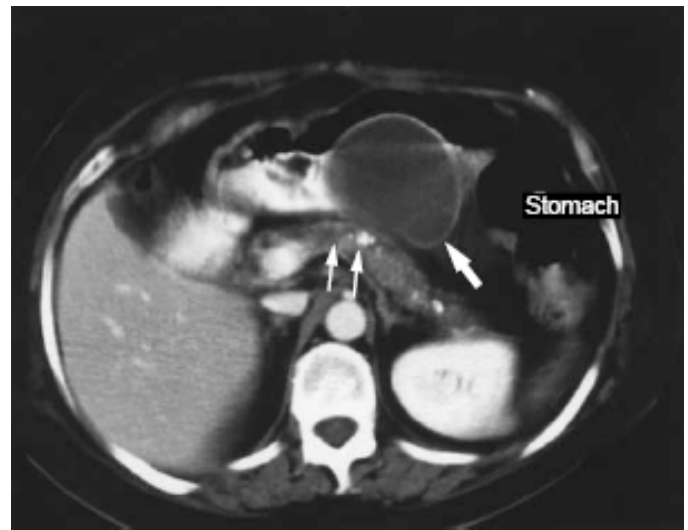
CT image showing pseudocyst (thick arrow) and abnormal pancreas (thin arrow)
